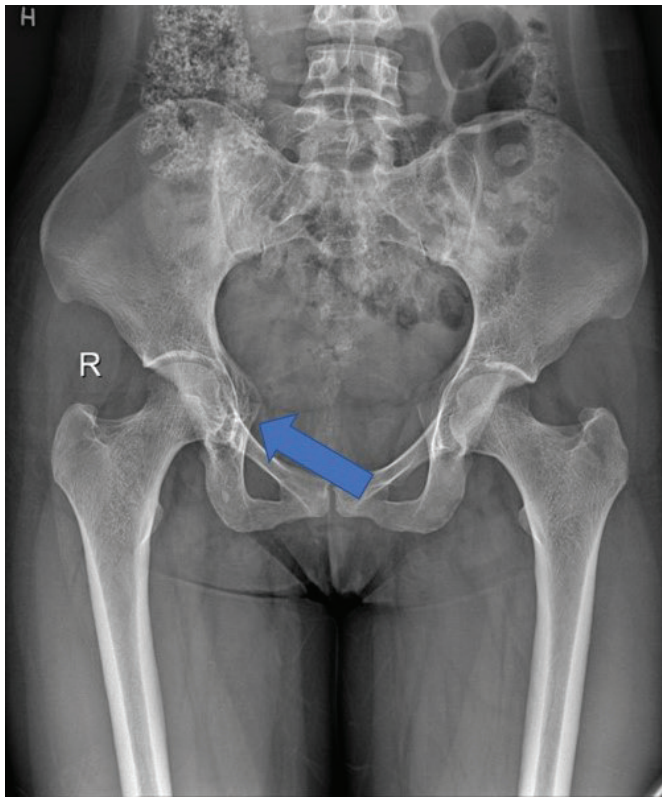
Xray Pelvis AP view shows a lytic lesion with internal trabeculations in the right ischium (arrow).
